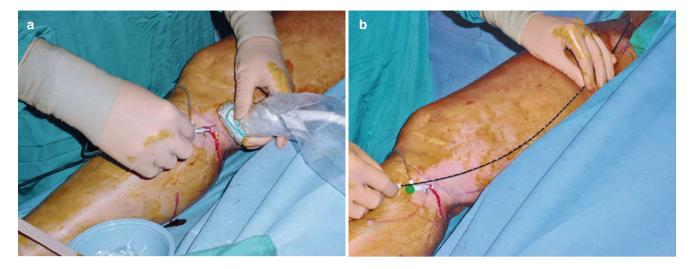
(a) Ultrasound guidance is used to identify the saphenous vein below the knee and for micropuncture technique to enter the vein and place the sheath. (b) As the catheter is passed up the saphenous vein, it can be visualized by duplex ultrasound
